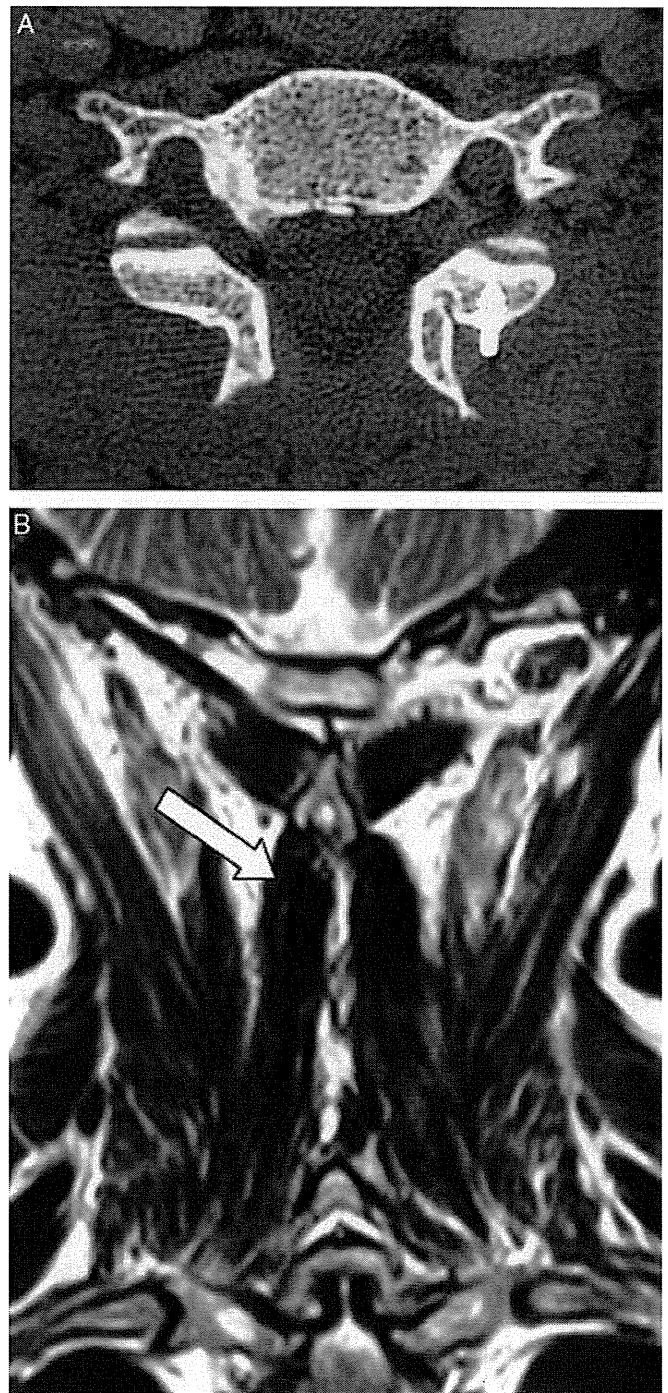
A and B, Postoperative axial computed tomographic image (A). Postoperative T2-weighted coronal magnetic resonance imaging demonstrates semispinalis muscle (arrow) preservation (B).
